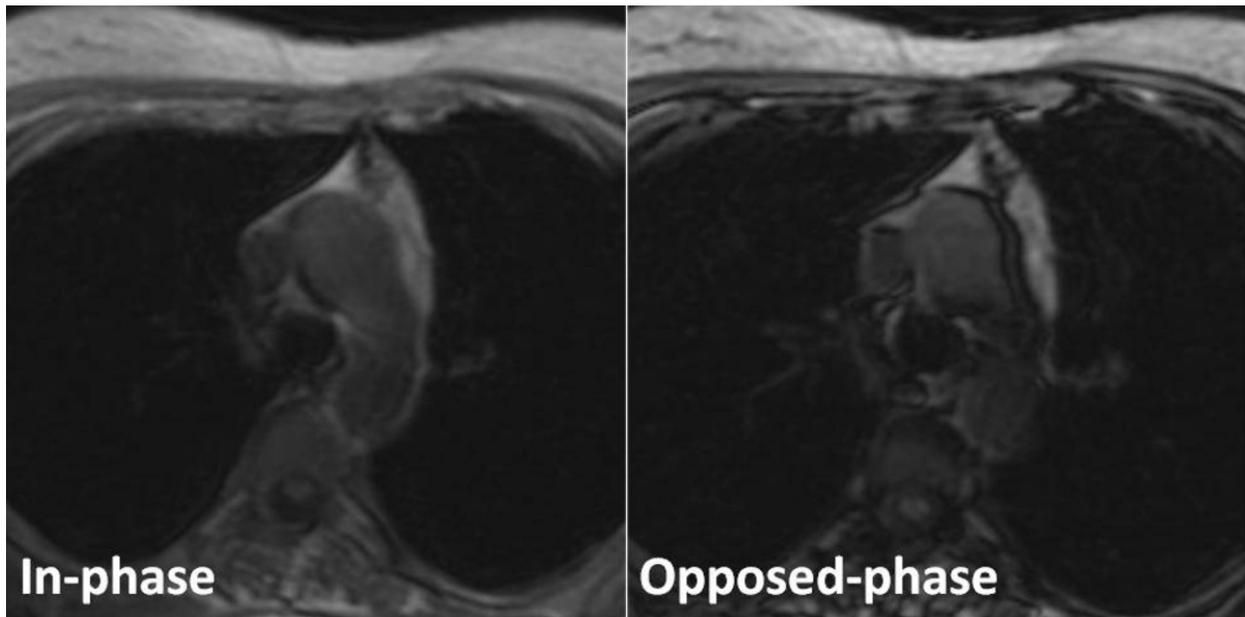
Thymic hyperplasia in a 40-year-old woman with myasthenia gravis. Transverse in-phase (155/4.6) and opposed-phase (155/2.1) gradient-echo T1-weighted MR images demonstrate an apparent decrease in signal intensity of the thymus gland on the opposed-phase image relative to the in-phase image. The CSR is 0.761.
